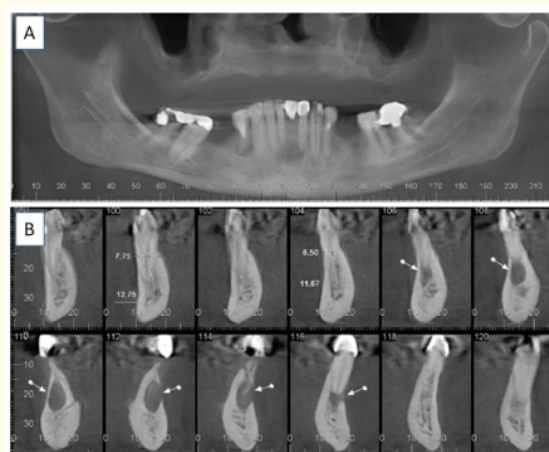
A) Panoramic CT image showing the lesion in the mandibular incisor region; B) CT sections 106 to 116 showing the dimensions of the lesion.
